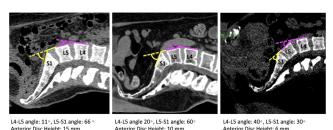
Computed tomography image examples of the L4-L5 and L5-S1 angle of descent relationships relative to the L5-S1 disc height.
